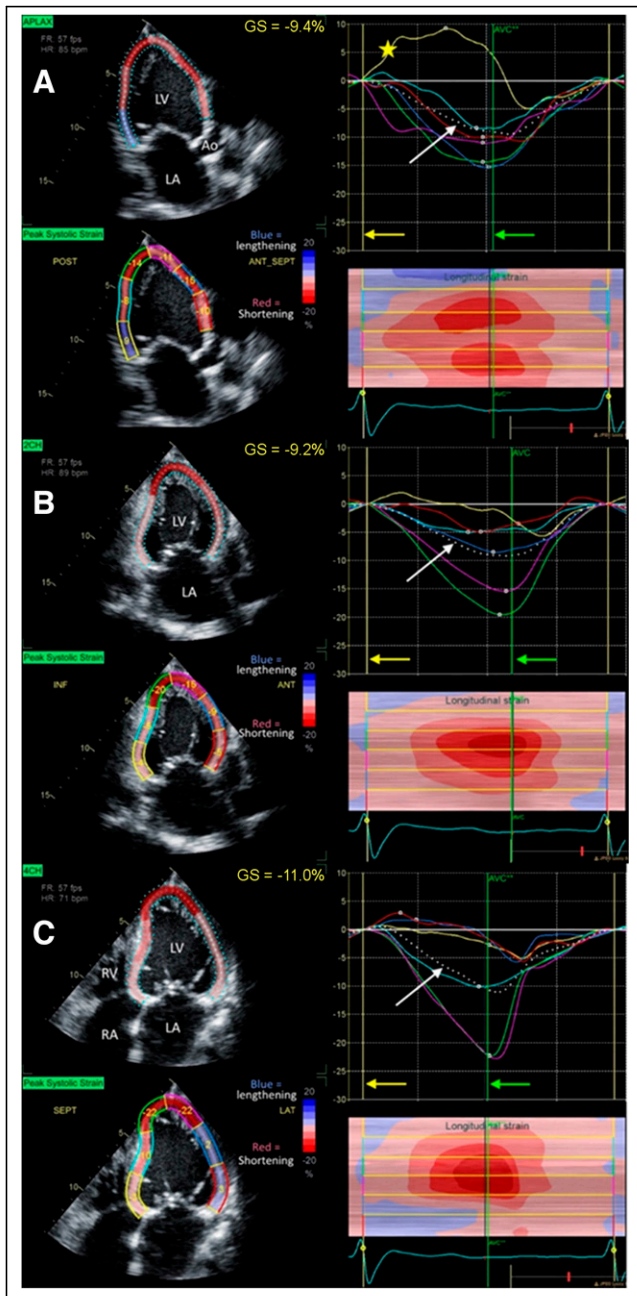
Resting TTE GLS. Rest 2D TTE strain measurements are from patient example in Figure 1. LVEF at rest was 32%, and GLS at rest was -9.9% . Three views—apical (A), 2-chamber (B), and 4-chamber (C)—are used in speckle-tracking echocardiography, and mean percentage longitudinal strain for each view is presented. Shades of red represent negative strain (contraction), whereas blue denotes positive strain (relaxation). White dotted line (white arrows) represents average strain among LV segments during cardiac cycle. Color of each trace line showing strain corresponds to anatomic color segments on 2D color image to left. Green arrows indicate aortic valve closure (AVC) line, which indicates end systole; yellow arrow shows end-diastolic (ED) line. Yellow star points out yellow curve on apical view; there is abnormal systolic lengthening of yellow segment (basal inferolateral segment). 2CH = 2-chamber; 4CH = 4-chamber; ANT = anterior; Ao = aorta; APLAX = apical long axis; FR = frame rate; GS = global strain; HR = heart rate; INF = inferior; LA = left atrium; LAT = lateral; POST = posterior; RA = right atrium; RV = right ventricle; SEPT = septal.
